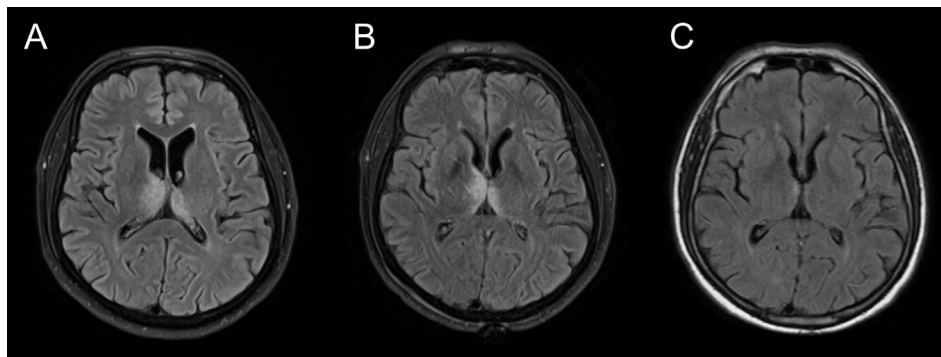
MRI series preoperative and in early follow up MRI follow up reveals the changes in hemodynamic conditions. Venous congestion with hyperintense regions bithalamic in FLAIR preoperative (A), in early postoperative MRI follow up (B) and regression 3 months after discharge (C).
